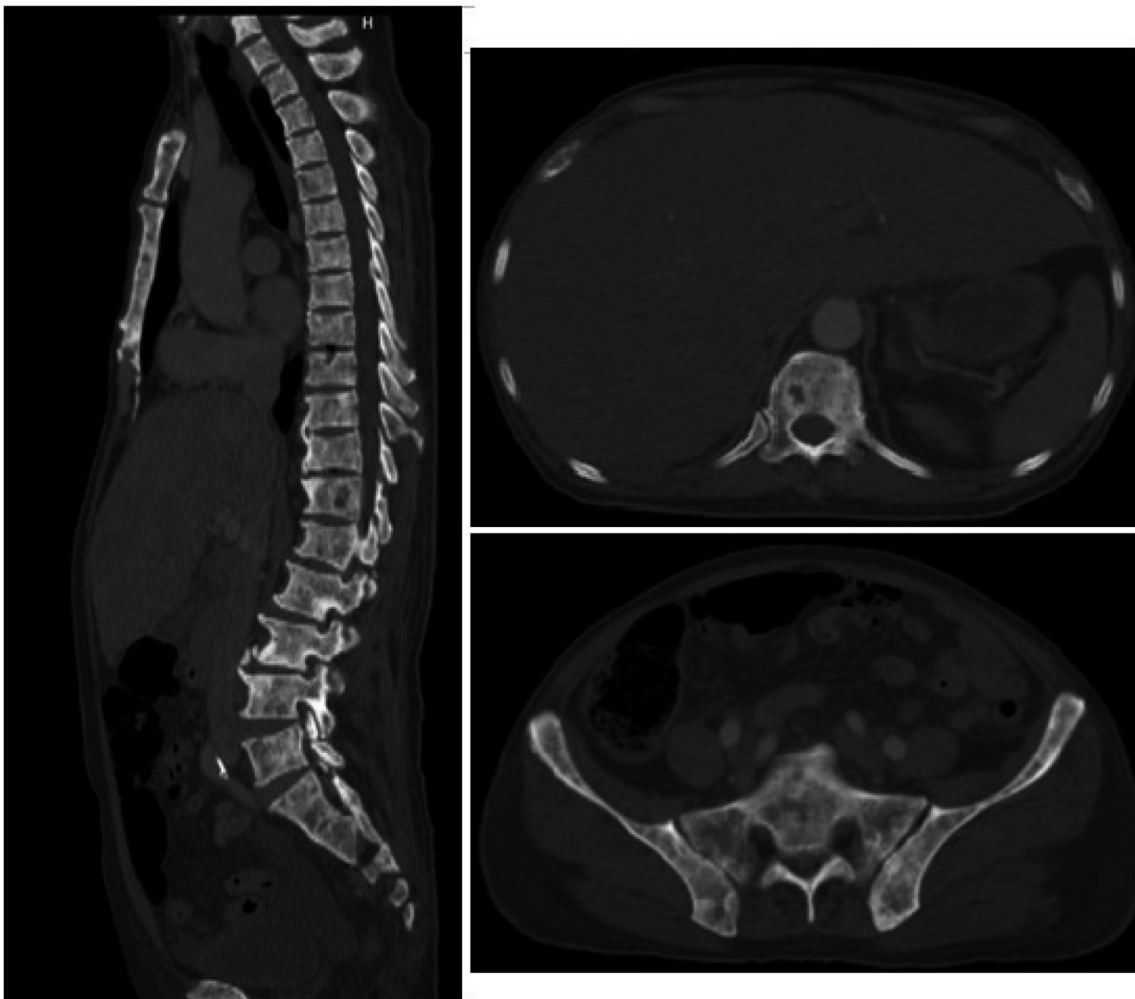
CT scans showed multiple combinations of osteolytic and osteoblastic metastasis in January 2022.
